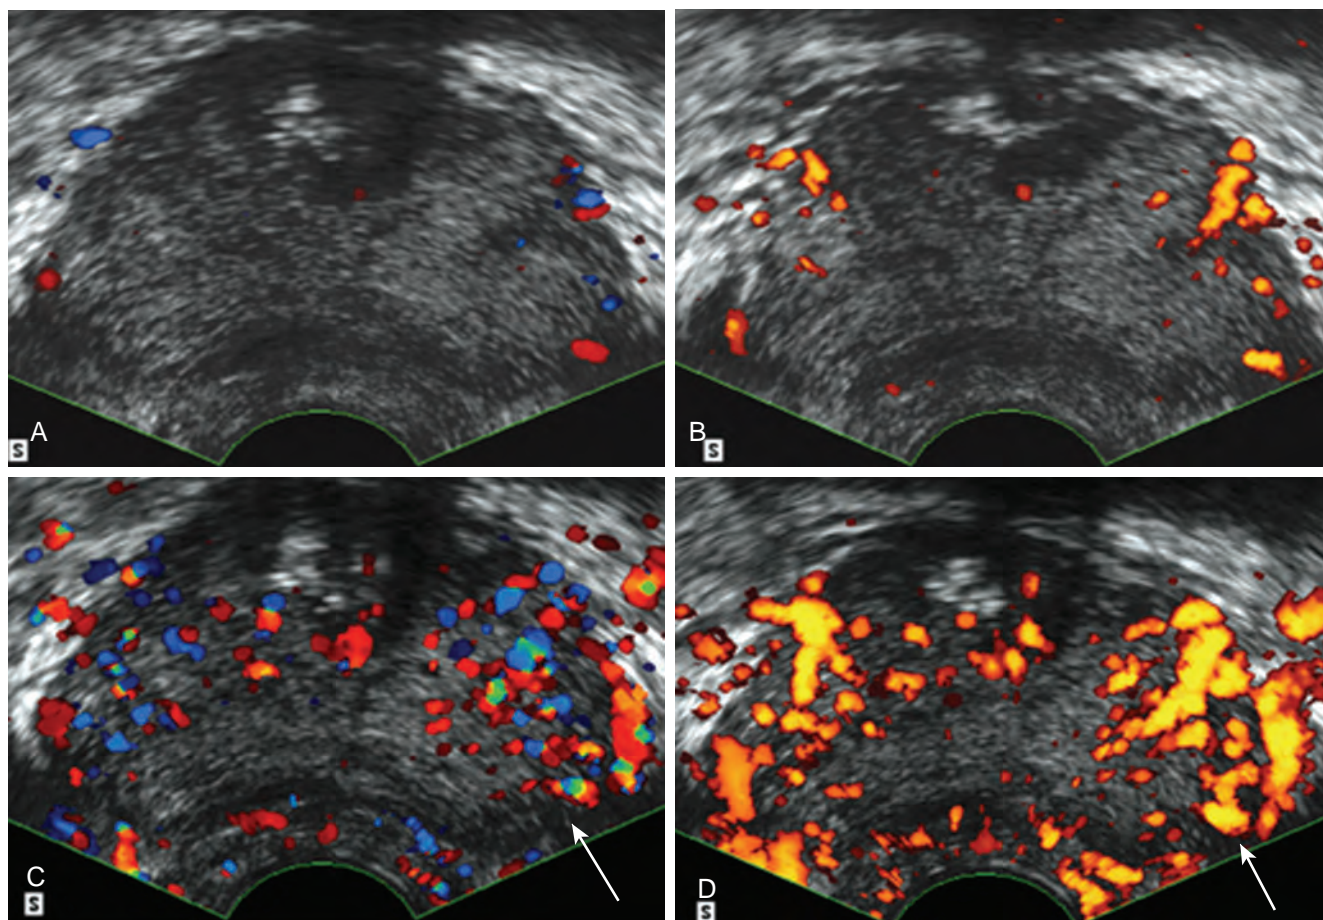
Unenhanced color (A) transrectal ultrasonography (TRUS) and power Doppler (B) TRUS fail to detect evidence of an underlying malignancy. After infusion of a microbubble contrast agent, color (C) TRUS and power Doppler (D) TRUS demonstrate an area of increased flow in the left mid-gland that proved to be a Gleason 3 + 4 = 7 adenocarcinoma on targeted biopsy (arrows).
